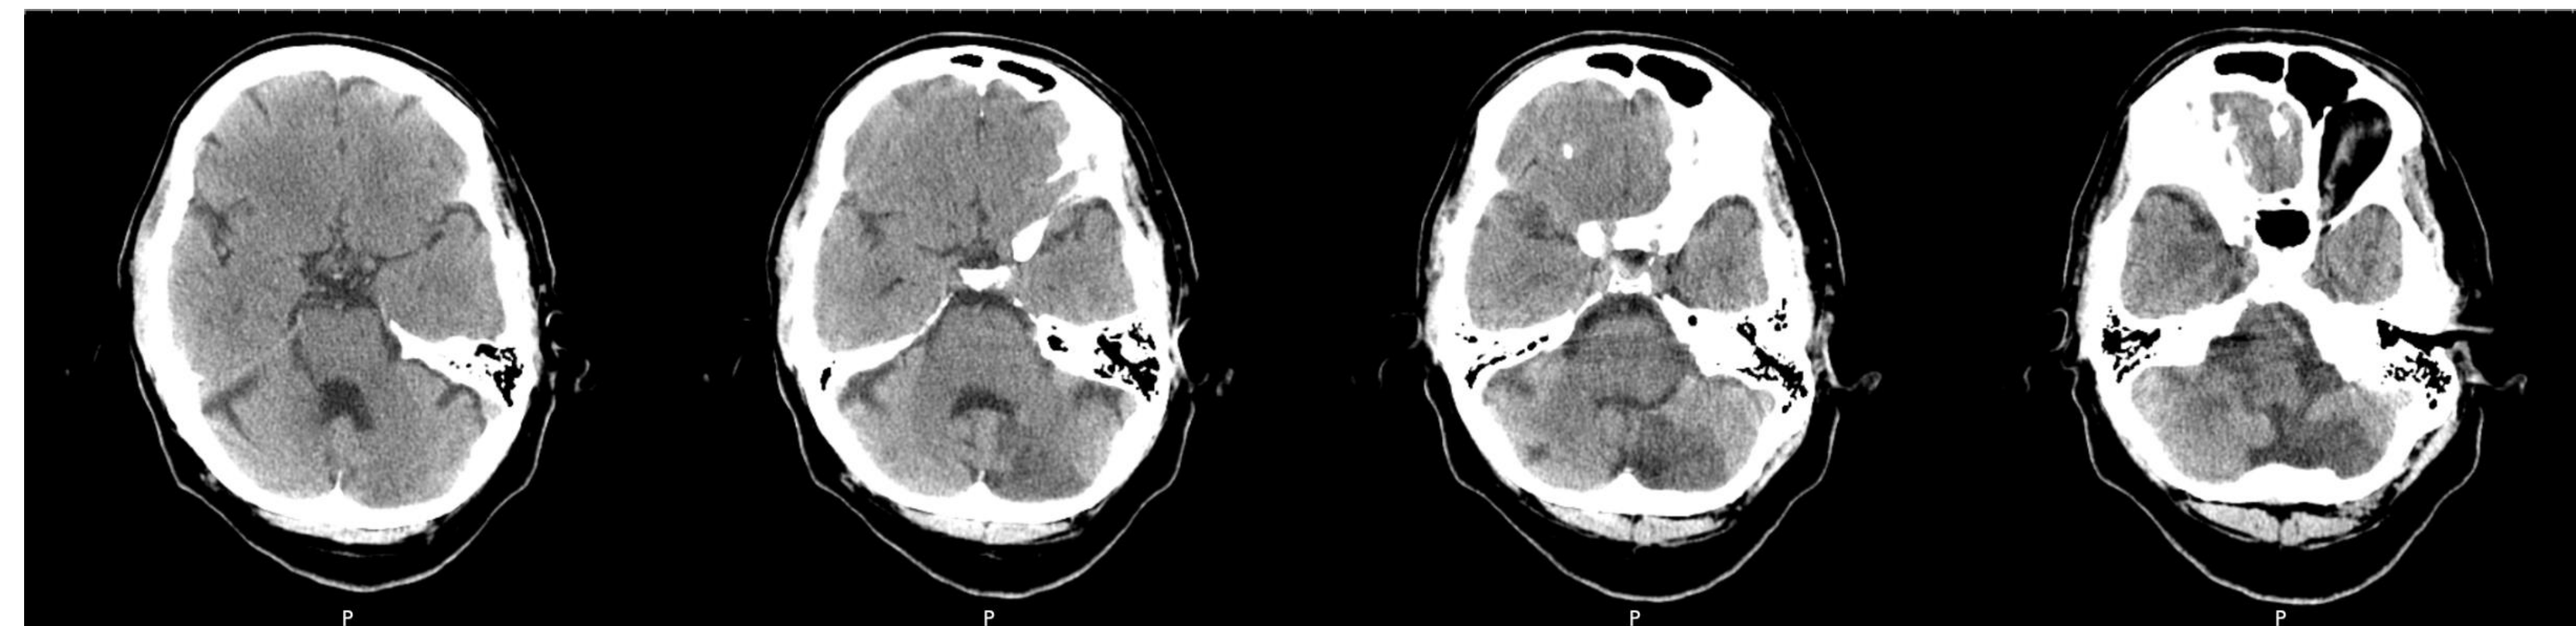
CT series showing hypoattenuation in the left posterior inferior cerebellar artery territory with chronic right inferior cerebellar infarcts
